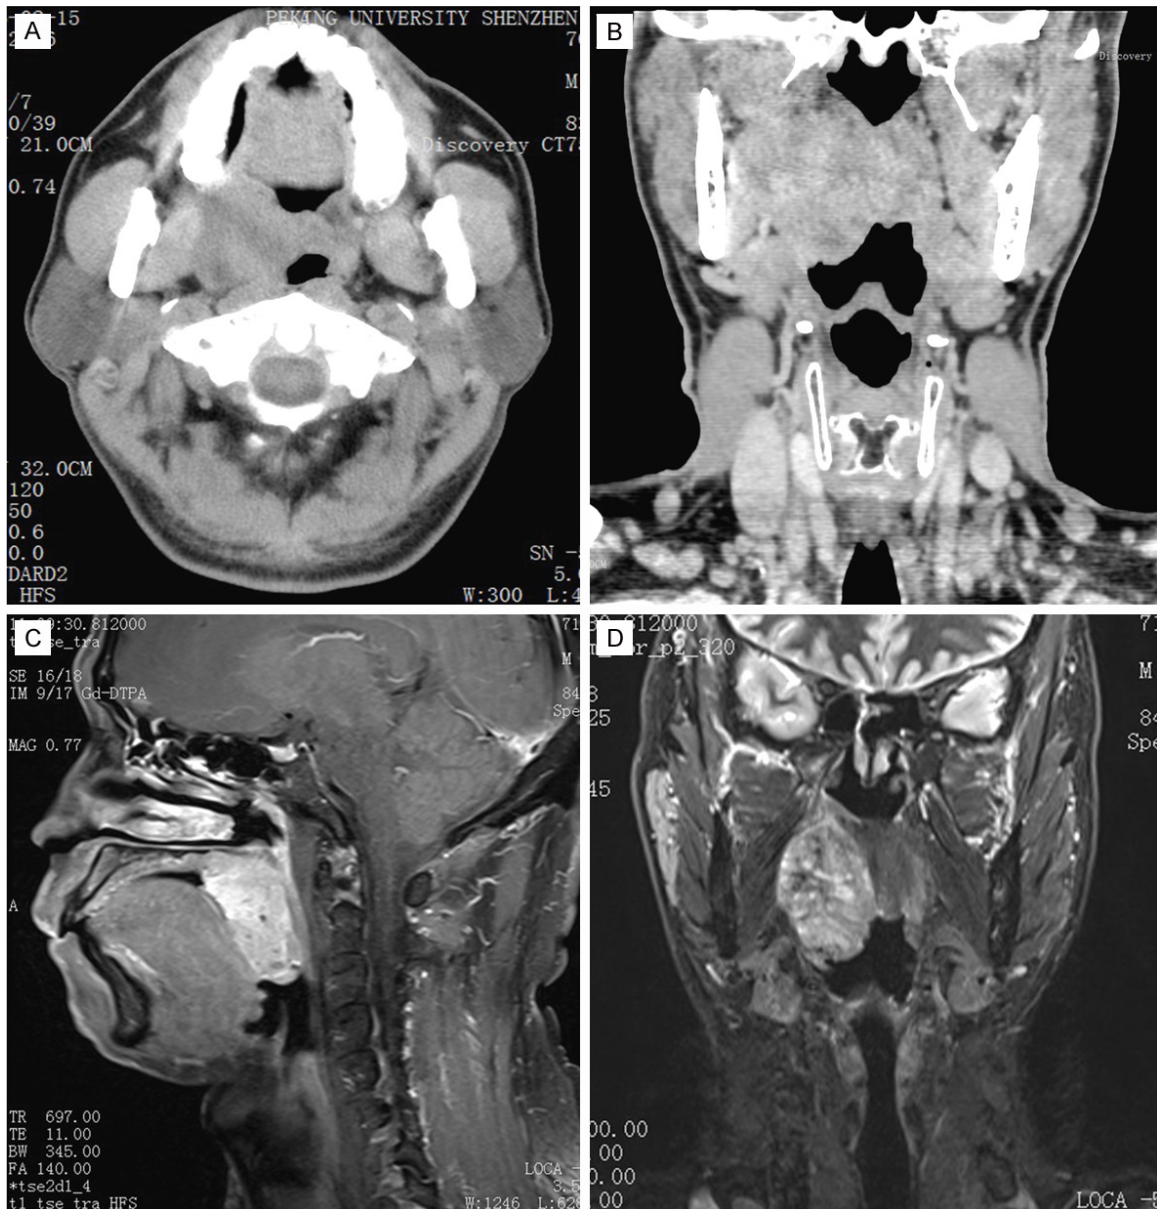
CT scan reveals a lesion in the right parapharyngeal space (A and B). MRI scan reveals a lesion in the right parapharyngeal space and invade to the soft palate and the oropharyngeal wall (C and D).
